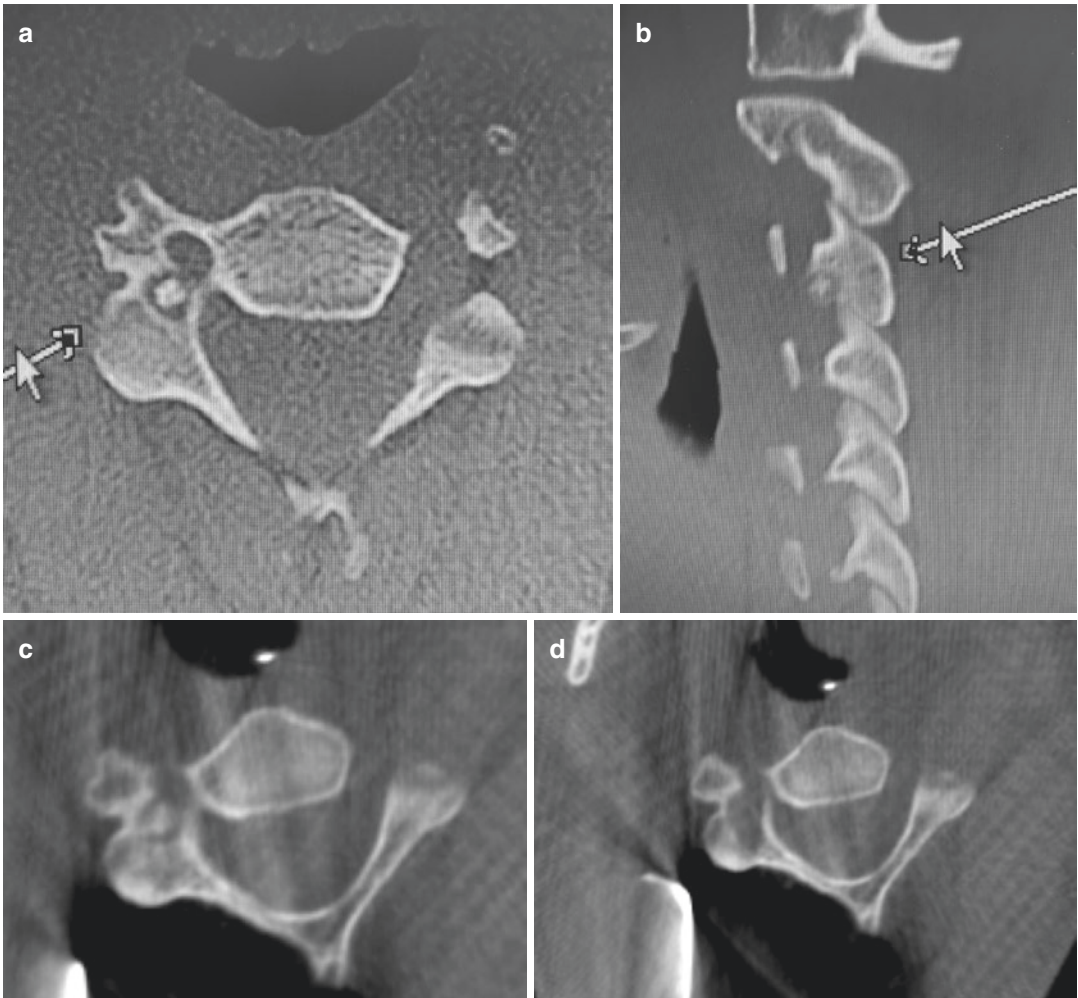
(a, b) Osteoid osteoma of C3 with close vicinity to the vertebral artery on a sagittal and axial CT scan. (c, d) Location precluded thermal ablation. Intraoperative
